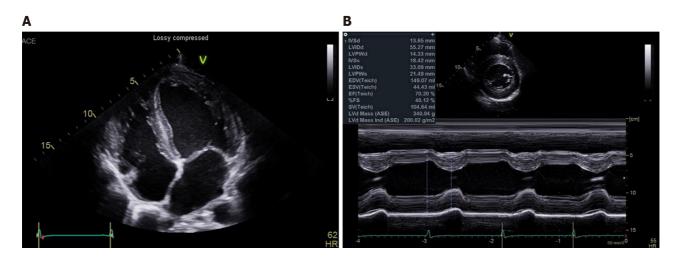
Echocardiographic images in the patient with Fabry disease. A: The apical 4-chambers view reveals brighten endocardium, slightly thickened mitral valves, and thickened left atrial wall; B: M-mode shows thickened left ventricular walls (up to 14 mm).
